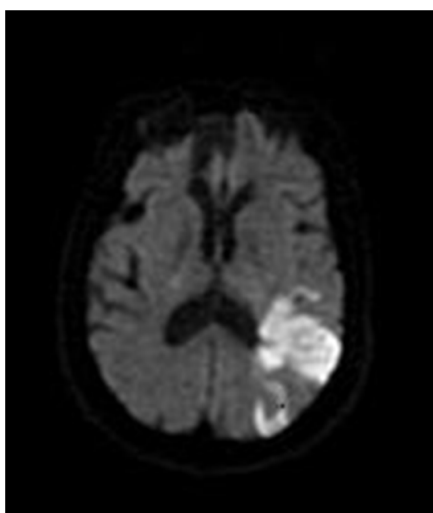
MRI of brain revealed multiple acute infarctions in left parietal and occipital lobes along with evidence of small focus of hemorrhagic conversion of left parietal infarction.
